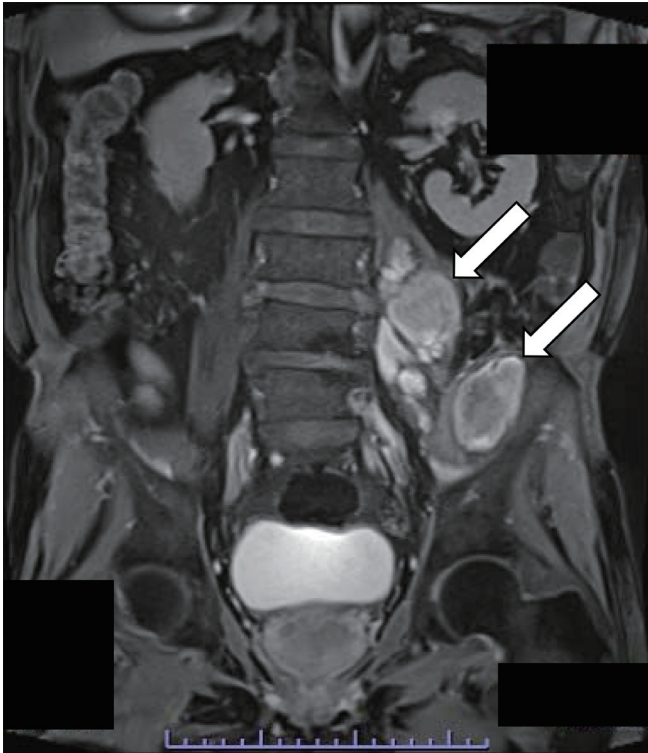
Abdominal CT images taken on day 29 showing enlargement of the left iliopsoas and psoas major muscles containing multiple masses.
